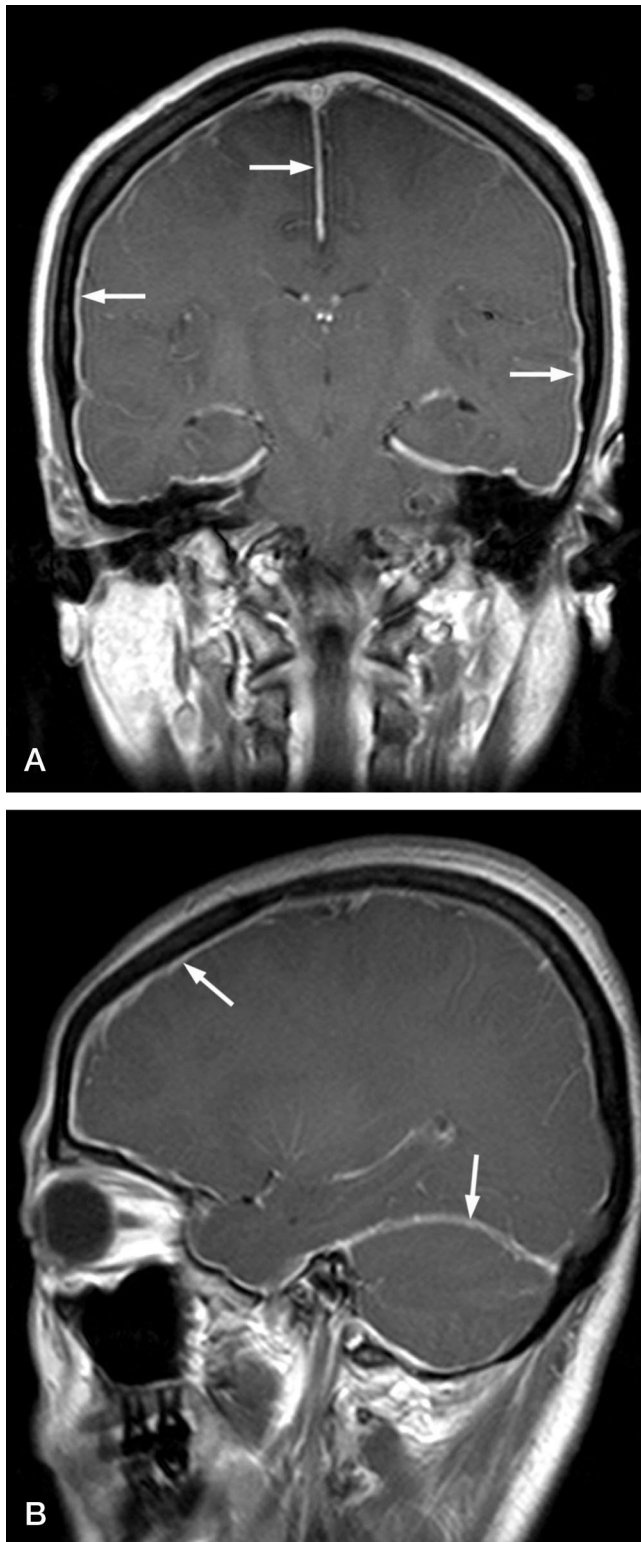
Contrast-enhanced coronal (A) and sagittal (B) MR images of the brain show diffuse pachymeningeal enhancement (arrows).
